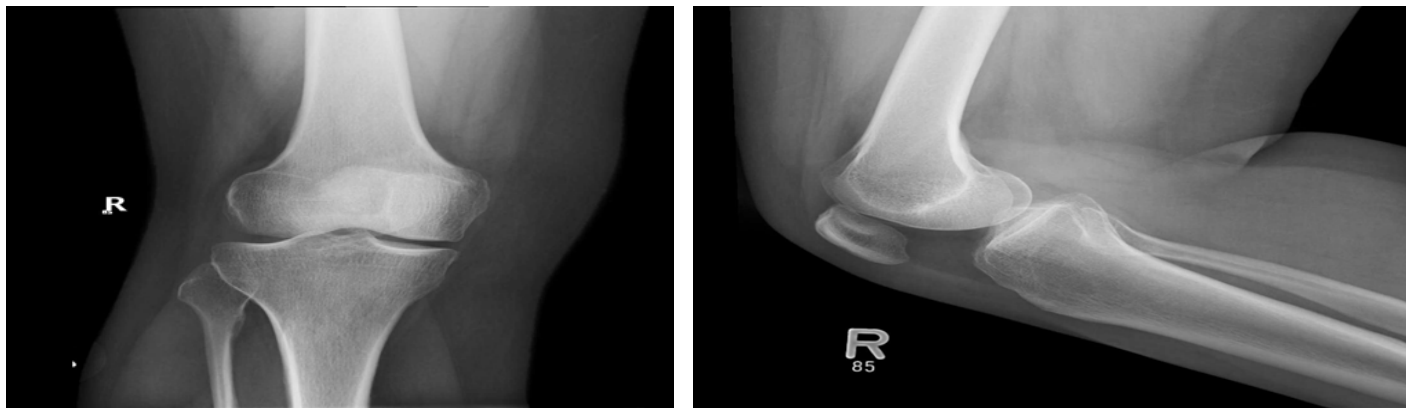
Plain Radiograph of the Right Knee Joint - Pre-operative plain radiograph of the right knee joint, in antero-posterior and lateral views, showed no bony or articular abnormalities, maintained joint space, normal bone density, no fractures, normal soft tissue shadow
